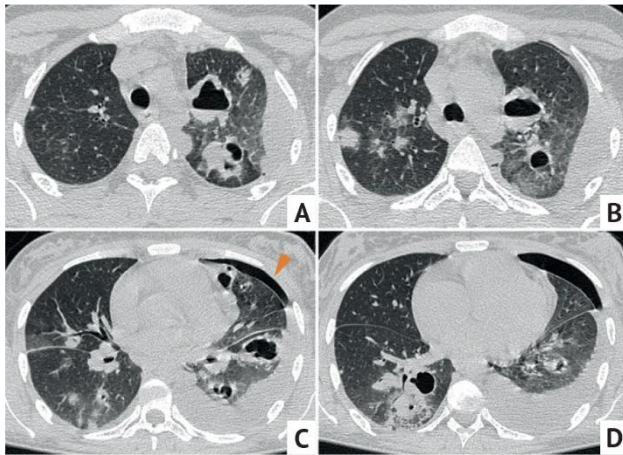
Axial chest CT images (A–D) of a 23 y.o. patient with sepsis (IE of the TV, pelvic abscess, SPE), HIV, hepatitis C. Lungs infiltrates and cavities, part of the cavities (in the upper left lobe) — with a horizontal fluid level. Acute chest pain on the left was the main reason for hospitalization, which was associated with air (arrow) and fluid contents in the pleural cavity (hydropneumothorax). The probable cause is a rupture of the subpleurally located cavities
